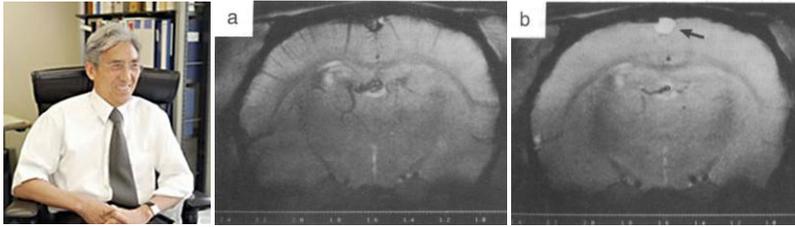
a) Seiji Ogawa, b) capture of some of the first MRI results with BOLD contrast, obtained by Ogawa et al. (1990)
